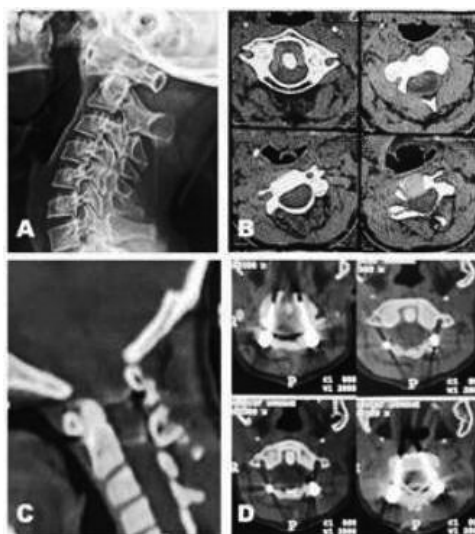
(A) Plain X-ray film of the cervical spine (lateral view) in a 15-year-old female patient showing atlantoaxial instability due to atlantoaxial rotatory fixation. (B) Cervical axial computerized (CT) scan of the same patient showing the rotatory fixation of C1 over C2. (C) Immediate postoperative sagittal CT scan of the cervical spine showed good alignment of C1 over C2. (D) Immediate postoperative axial CT scan of the cervical spine showed reduction of the rotatory fixation with the C1-2 screws.
